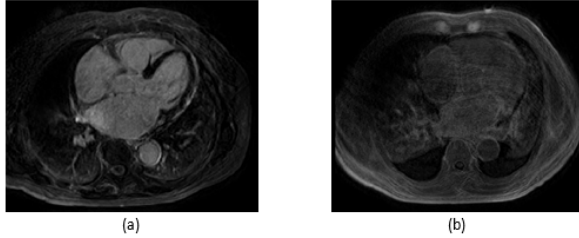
DE-MRI images of different patients. (a) DE-MRI with high contrast (b) DE-MRI with low contrast.
